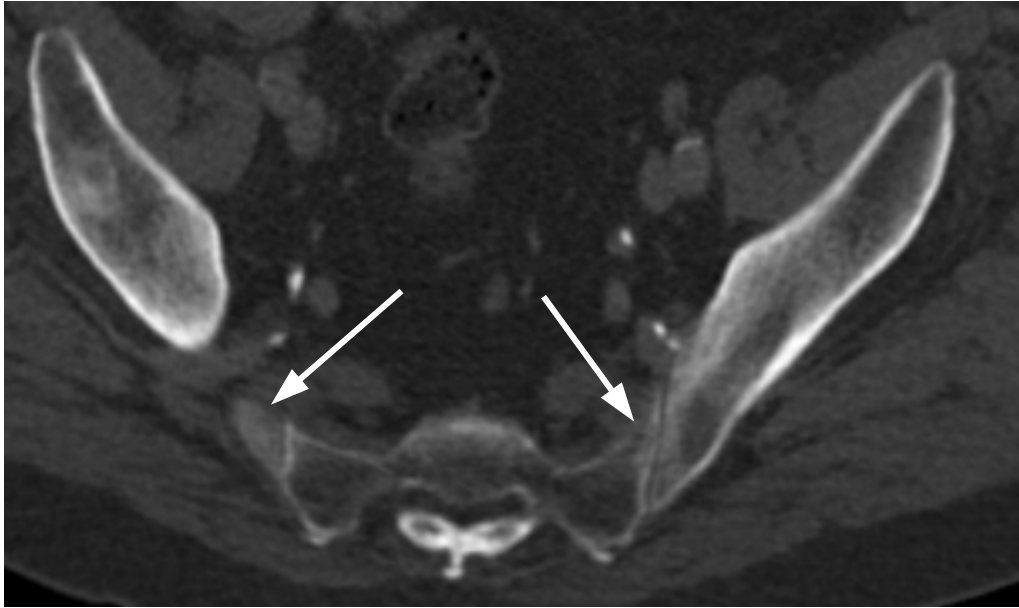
A CT scan of the pelvis. Bone segmentation in CT images can be difficult as bony regions and boundaries are not always well defined. The white arrows point to areas of bone that are difficult to segment. The underlying CT data is from the Addenbrooke's Hospital CT Data Collection.
